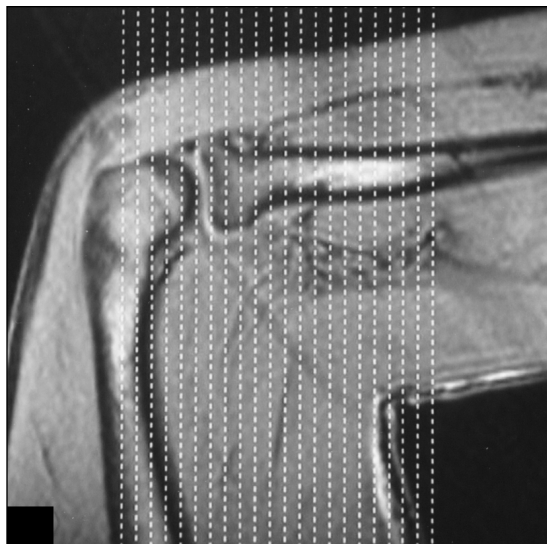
Localizer MR image with lines shows slice positioning for flexed abducted supinated view. Notice sections, sagittal to long axis of body but coronal to anatomy at elbow. Ideal angulation is planned along distal biceps brachii tendon, but often, as here, this structure is not clearly visible on localizer images. In this case, sections nearly perpendicular to radius provide reasonable and reproducible imaging plane.
